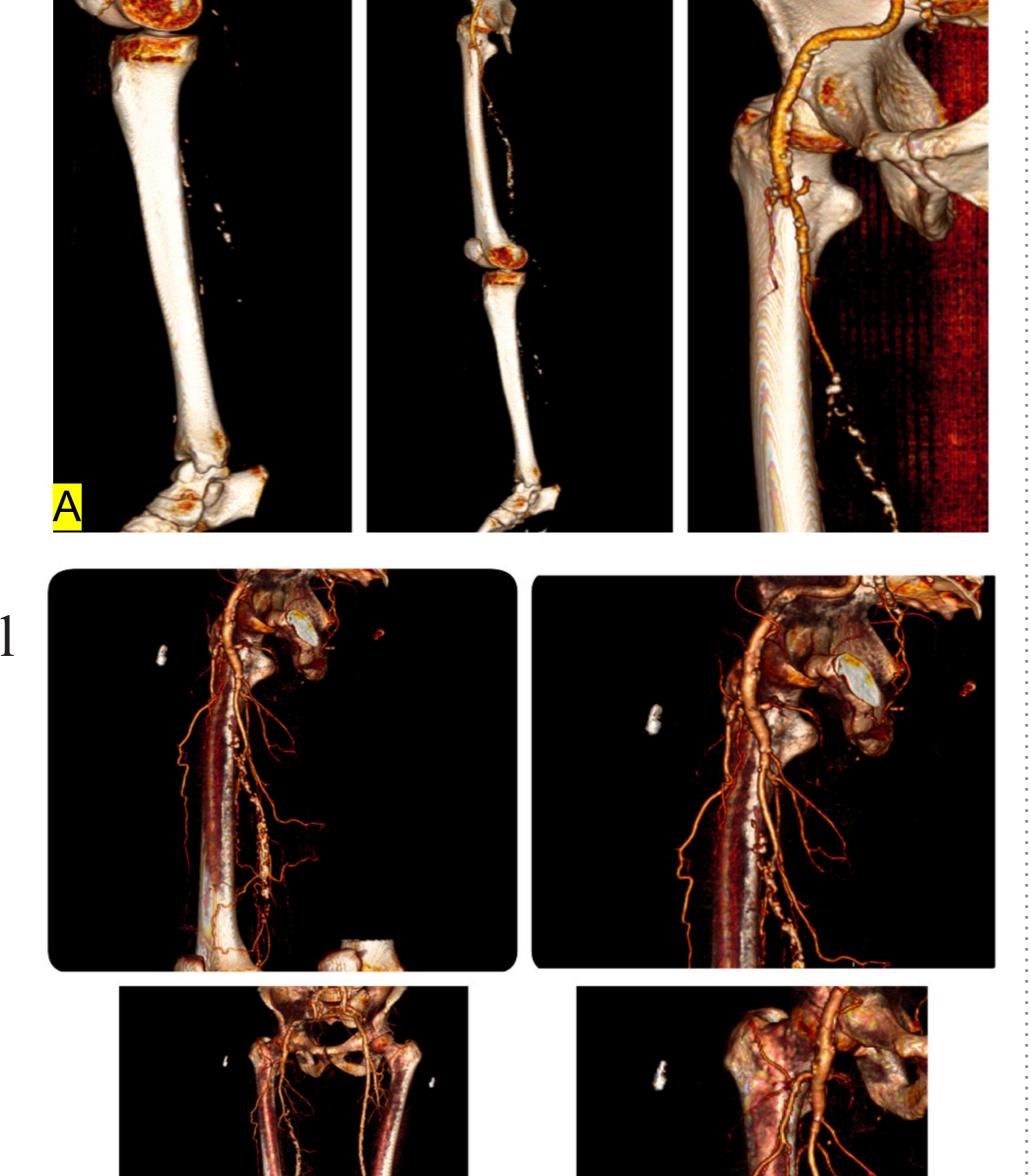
FPS thrombosis, deep femoral artery stenosis, absence of distal bed. B-CT-angiography after reconstruction
